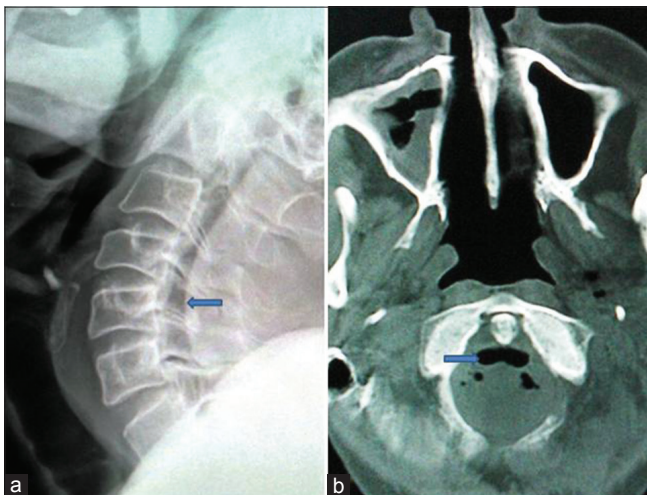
X-ray cervical spine – lateral view (a) and computed tomography scan – axial view (b) Pneumorrhachis (shown by arrow)
